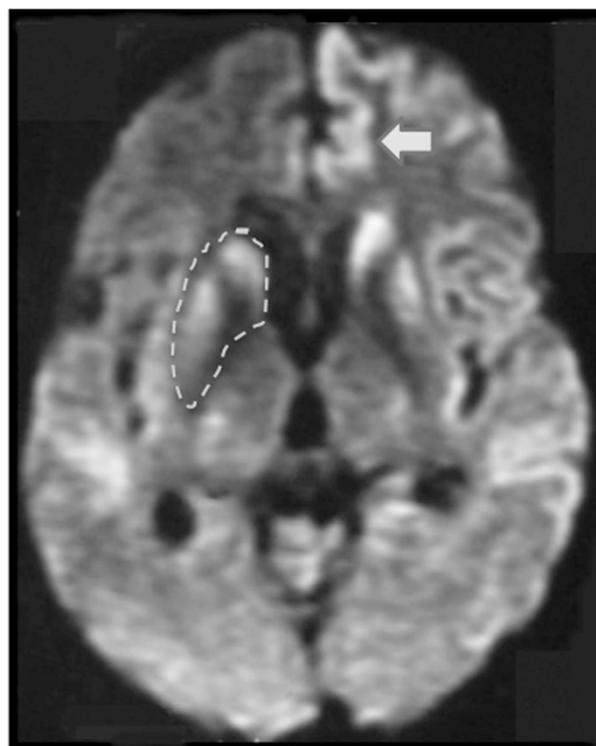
Diffusion weighted brain MRI of CJD. Hyperintensity of the cortical ribbon (arrow) and basal ganglia (dotted line) are characteristic of sporadic CJD. Although the available data are limited in genetic prion disease, because of its lower incidence, this finding seems to be less common to genetic prion disease.
